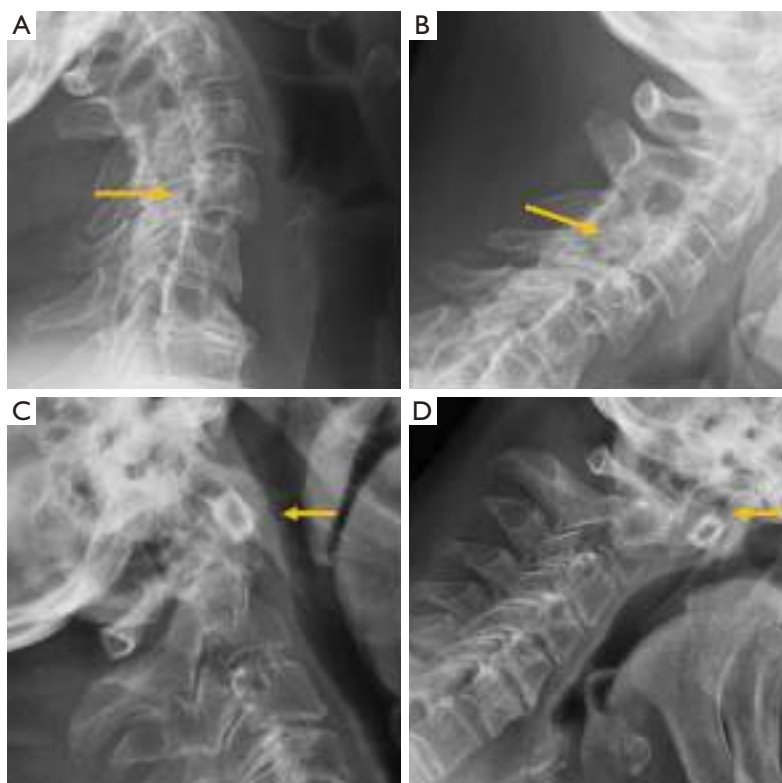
Subaxial cervical instability. Extension (A) and flexion (B) radiographs showing 4 mm forward displacement of C4. Atlantoaxial joint instability. Extension (C) and flexion (D) radiographs showing 4 mm forward displacement of the anterior arch of the atlas. Arrows point the main abnormality in each case.
